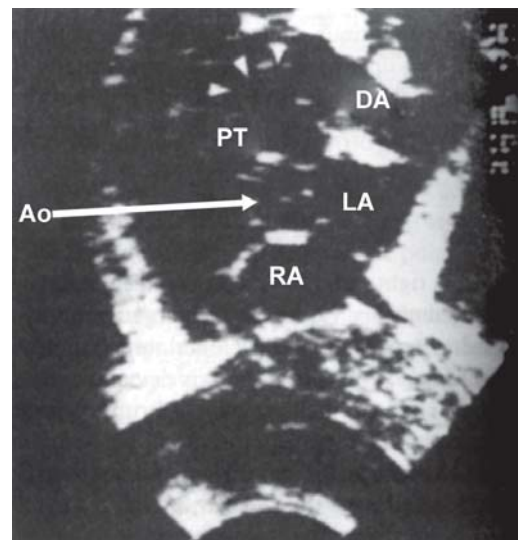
Echocardiography (two-dimensional) in PDA
